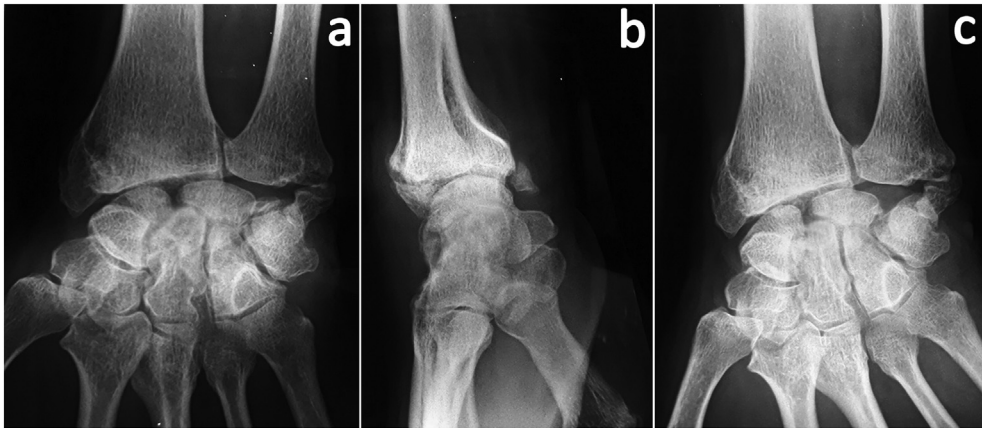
Posteroanterior (a), lateral (b) and ulnar deviation (c) radiographs 25 months after surgery.
